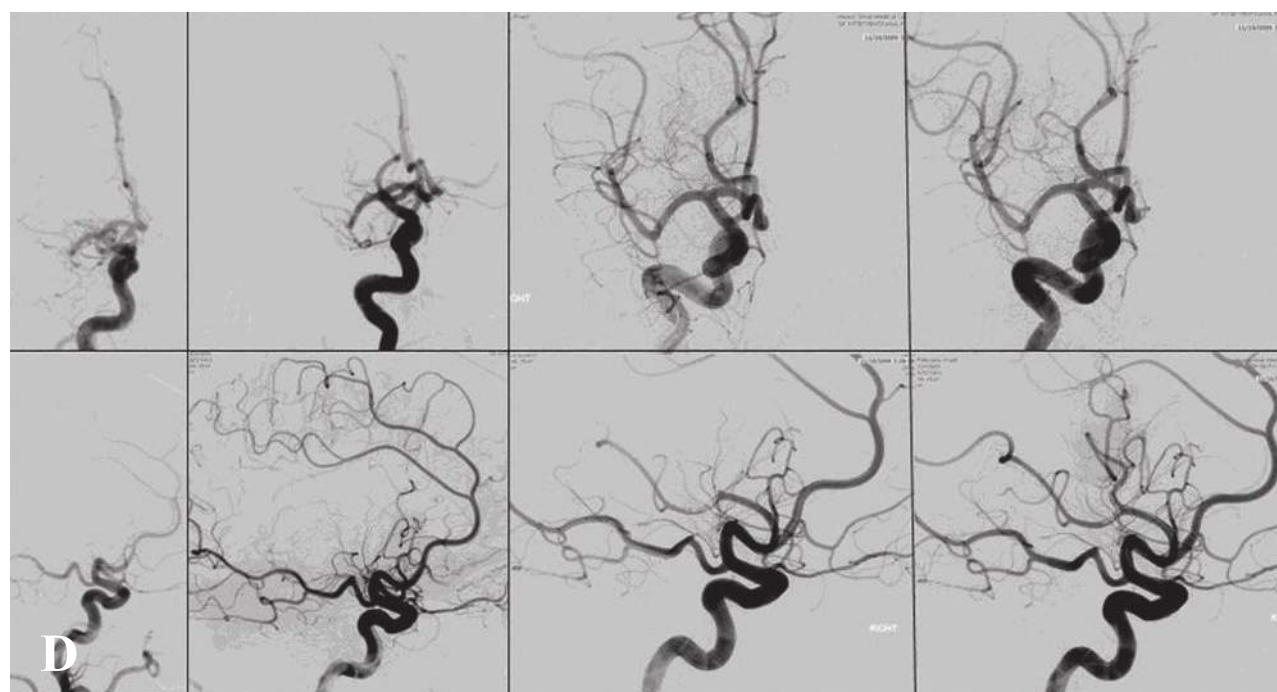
(A–D) A 46-year-old man presented with left face, arm, and leg hemiplegia (NIHSS 20). CT demonstrates no hemorrhage. CT perfusion demonstrates elevated mean transit time (MTT) in the right MCA territory. CTA demonstrates occlusion of the right distal M1/proximal M2 segment. Angiography confirms the occlusion despite intravenous rt-PA. The occlusion was recanalized successfully with 11 mg intra-arterial rt-PA and wire disruption of the clot. Postprocedure, the patient’s residual deficit was mild nasolabial flattening.
